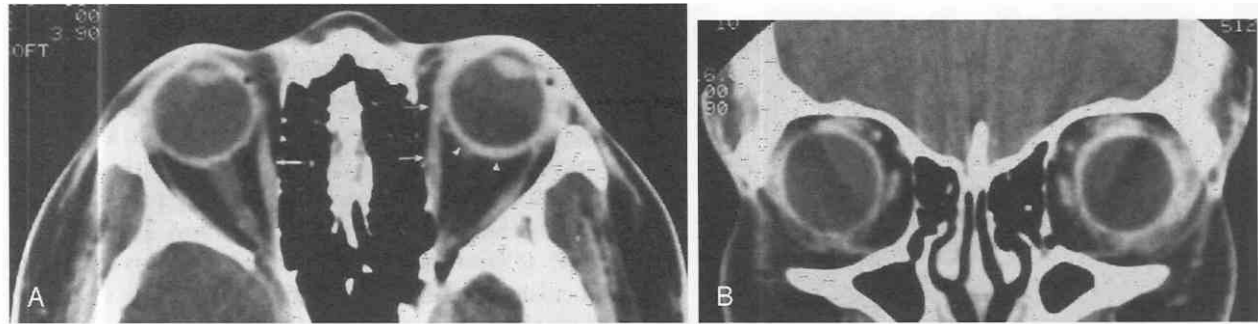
A, Axial CT scan shows pseudotumor of the orbit with swollen bilateral medial rectus (*arrows*), which includes tendinous insertion on the globe. Thickening and enhancement of the globe (*arrowheads*) are also shown. B, Coronal CT scan shows pseudotumor of the orbit (same patient as in A).
